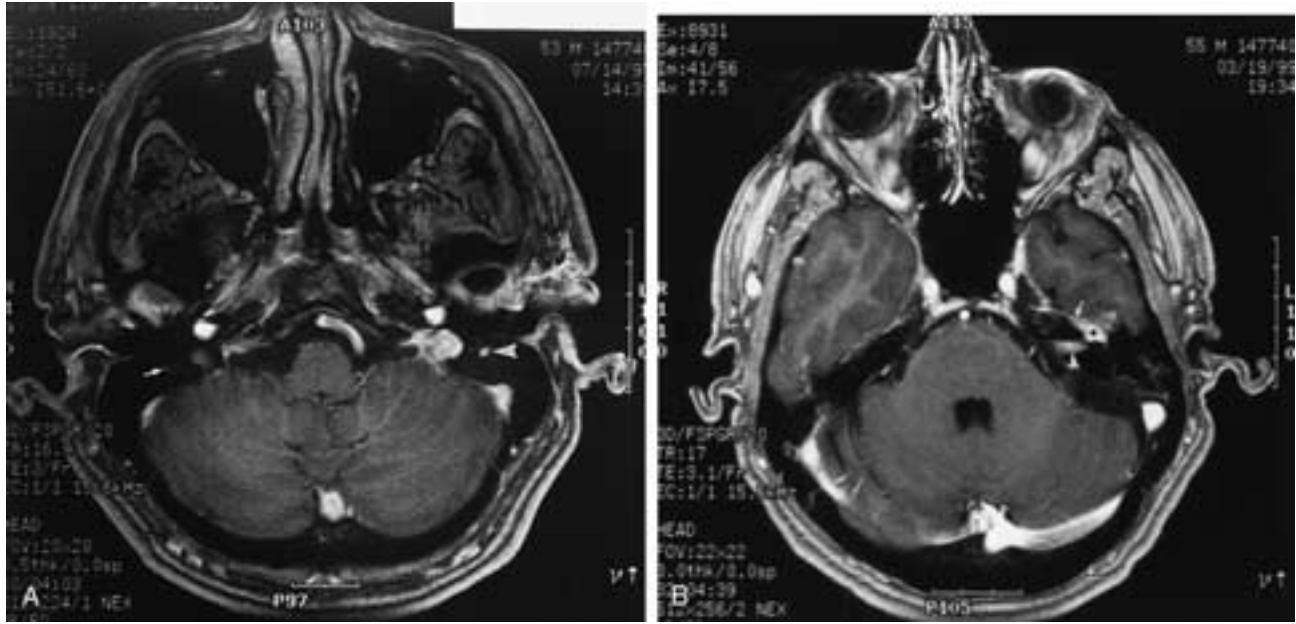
Adenocarcinoma of the left parotid gland with PNS along the facial nerve. A, Axial contrast-enhanced SPGR MR image obtained at an outside facility 1 month after left parotidectomy. The facial nerve was paralyzed postoperatively. This study was read as postoperative changes only; no mention was made of the abnormal enhancement and enlargement of the left descending facial nerve segment (*arrowhead*). The right descending facial nerve is normal (*arrow*). The tympanic and more anterior aspects of the left facial nerve are normal. Postoperatively, the patient had radiotherapy to the parotid region. B, Axial contrast-enhanced SPGR MR image obtained at an outside facility 20 months after A, by which time the patient had developed left-sided hearing loss. There is tumor in the geniculate ganglion (*black dot*), proximal greater superficial petrosal nerve (*arrow*), and internal auditory canal (*arrowhead*). This case demonstrates progression of PNS with initial failure to diagnose. The patient ultimately developed widespread leptomeningeal disease.
